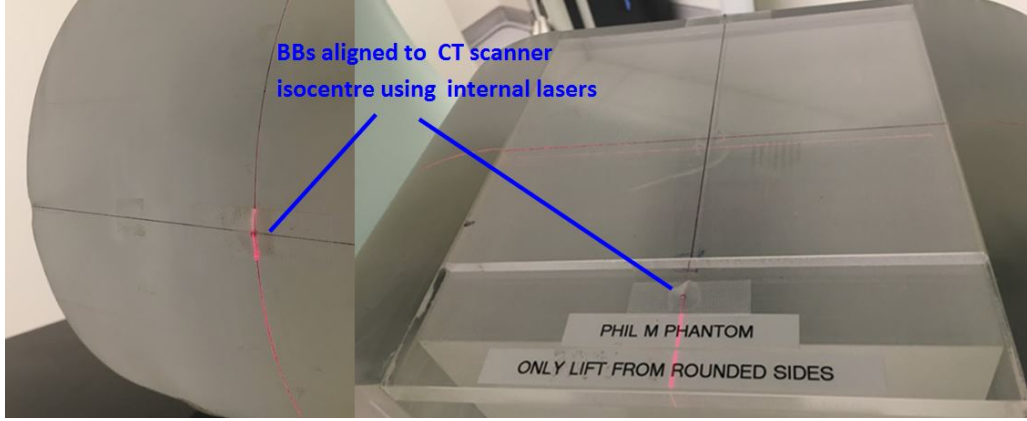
BBs stuck onto external markings of MattL, aligned to CT isocentre using the CT bore internal lasers.
